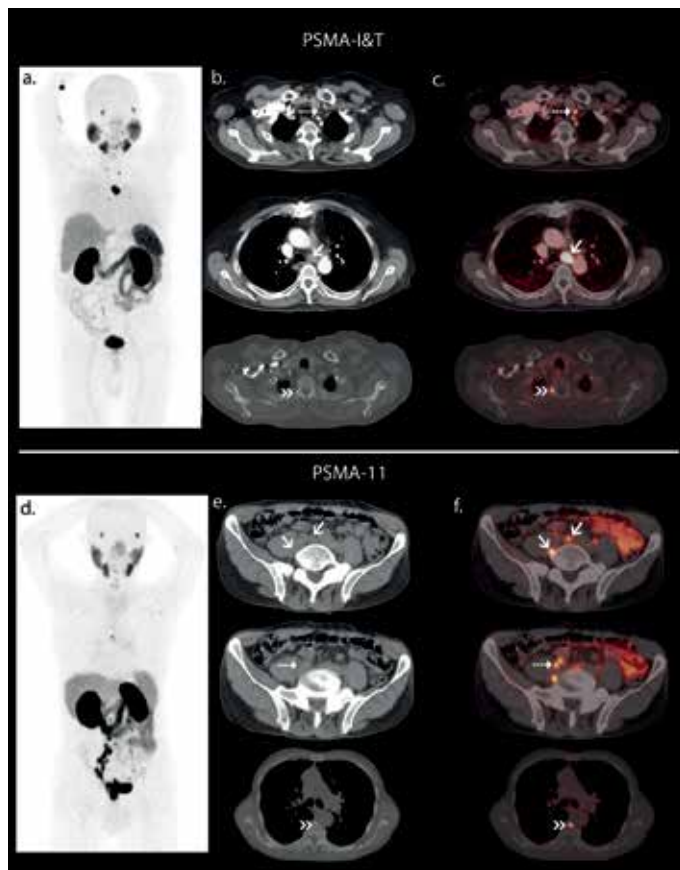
a-f. PSMA positron emission tomography/computed tomography images of two patients with recurrent prostate cancer showing metastatic lymph nodes (dotted and dashed arrows) and single bone metastasis (chevron arrows). Both tracers were able to show lymph nodes as small as 5mm (dashed arrows). Figure labels: maximum intensity projection (a), axial CT slices (b), PET and CT fusion slices (c) of ^{68}Ga -PSMA-I&T; Maximum intensity projection (d), axial CT slices (e), PET and CT fusion slices (f) of ^{68}Ga -PSMA-11
